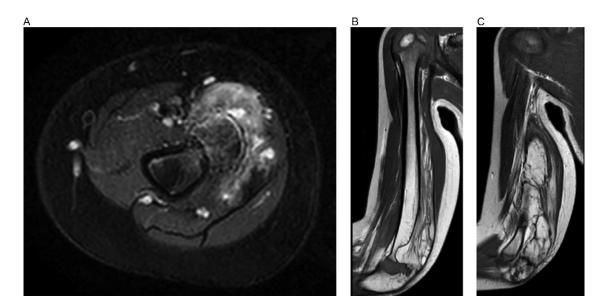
MRI without Gadolinium enhancement of the right elbow after 2 years of observation, at 4 years and 8 months of age. Axial stir (A) and 2 cuts of sagittal T1-weighted sequences (B, C) demonstrating the ossified mass replacing the fibers of the triceps muscle.
